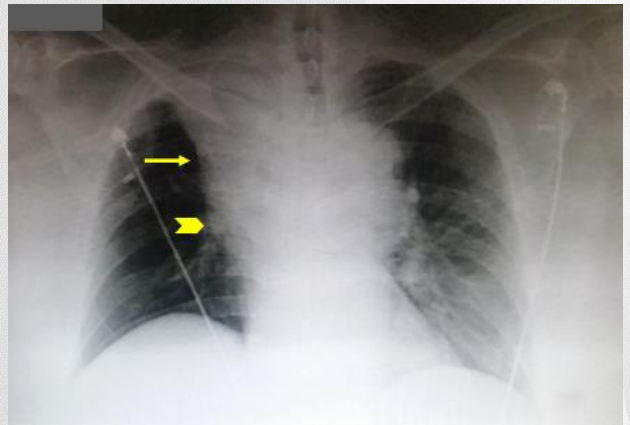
Postero-anterior chest radiograph showing right upper lobe atelectasis (yellow arrow) and a suspicious right hilar density (arrowhead)
